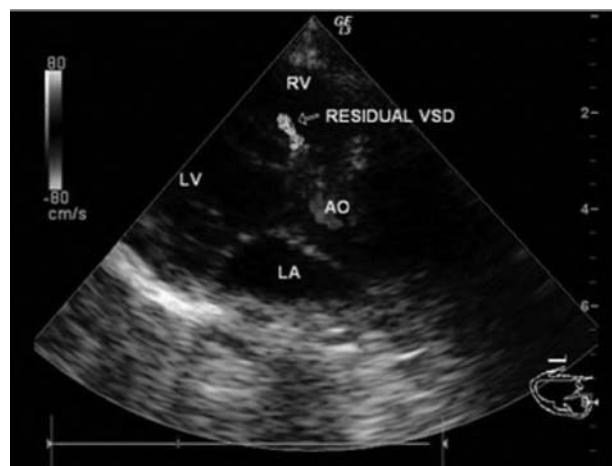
Post-procedure echocardiography showed coil in situ and small residual VSD.
